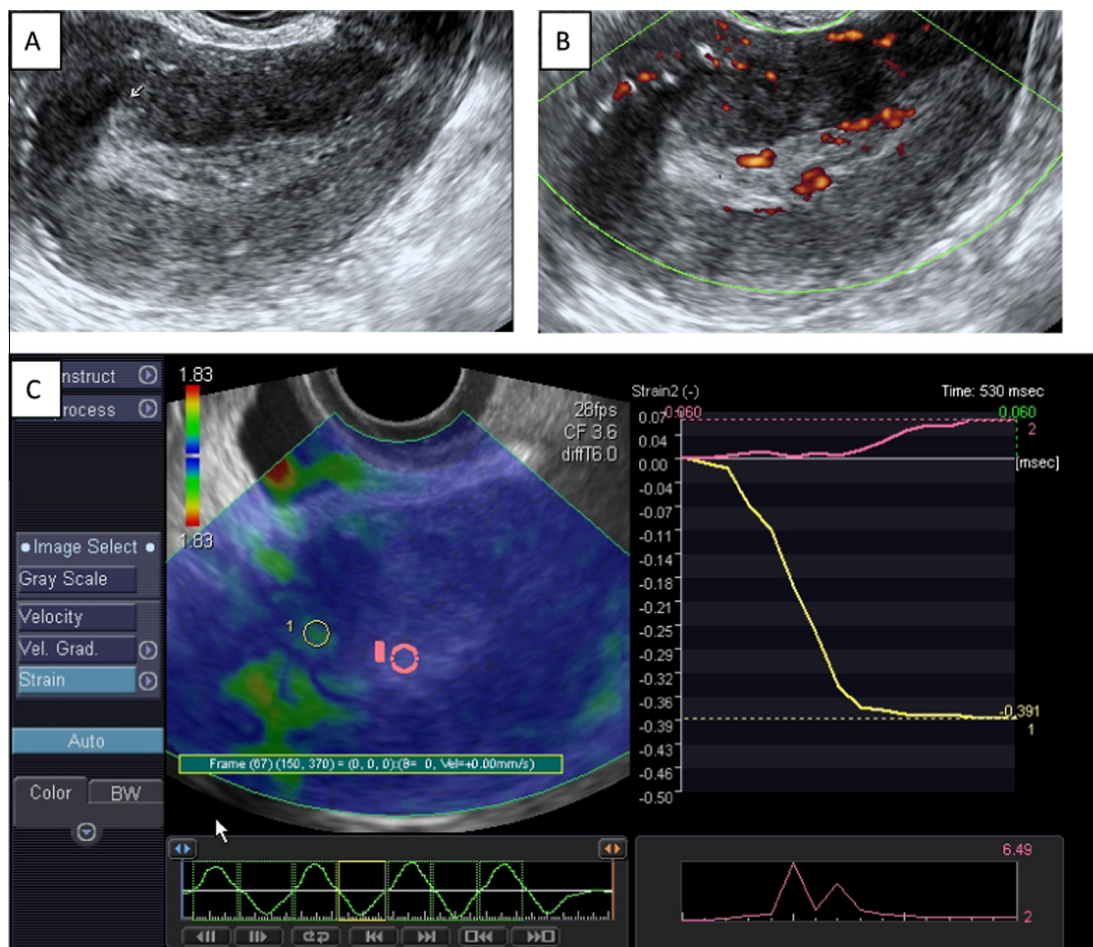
Ultrasound images of a female patient, aged 63 years with thickened endometrium (confirmed to be atypical endometrial hyperplasia by pathological examination). B-mode ultrasound image (A), Power Doppler image (B) and TV elastogram (C) show endometrial thickness = 17 mm with mild increase vascularity, light blue color and SR = 6.49.
